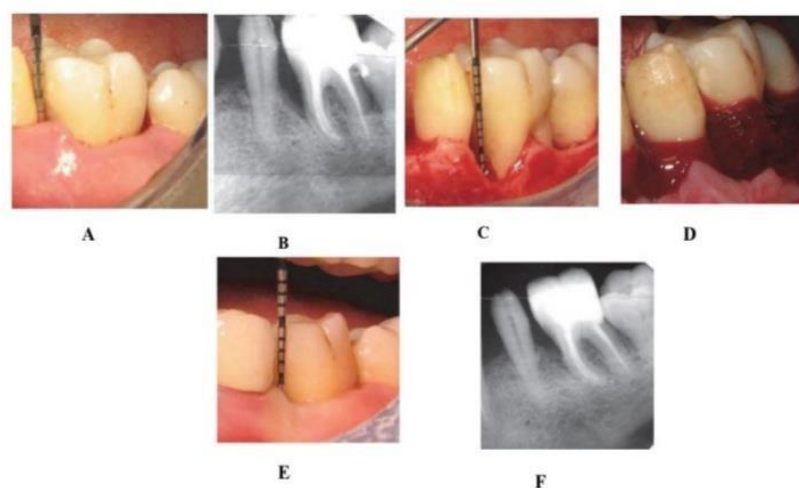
A: Initial clinical view of the intrabony defect and probing depth, B: Initial radiographic view of the intrabony defect, C: Intrasurgical measurement of the intrabony defect, D: Application of PRP alone, E: 12- months clinical view of the intrabony defect and probing depth, F: 12-months radiographic view of the intrabony defect. (58).
